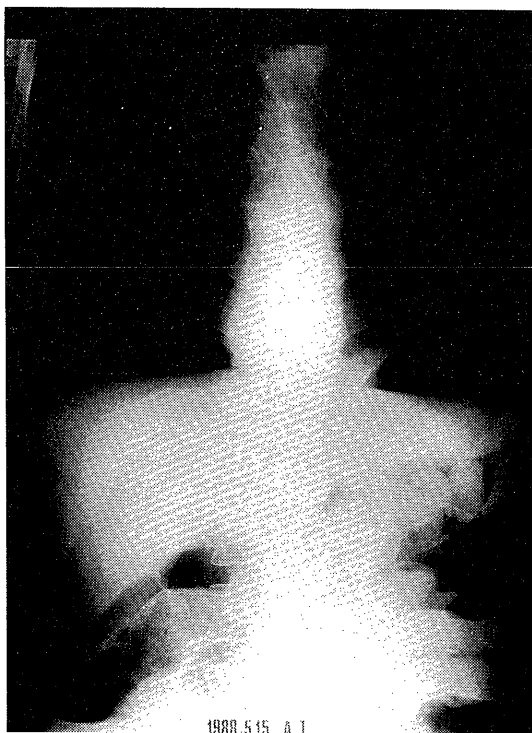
Preoperatively abdominal X-ray film, showing a presence of free gas in the left subphrenic space.
